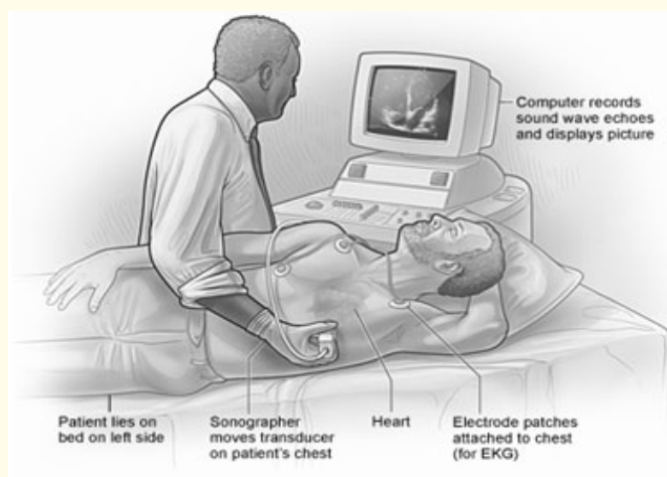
Echocardiograph.
